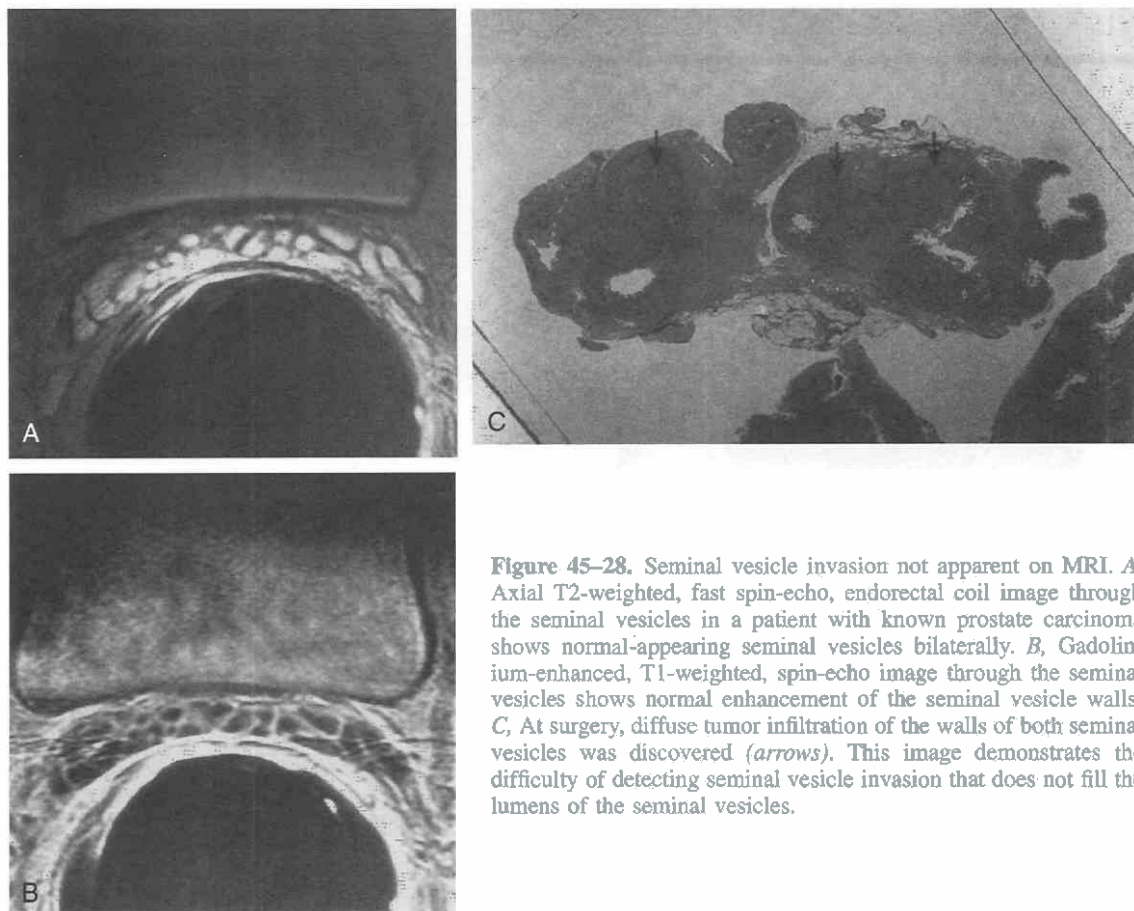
Seminal vesicle invasion not apparent on MRI. *A*, Axial T2-weighted, fast spin-echo, endorectal coil image through the seminal vesicles in a patient with known prostate carcinoma shows normal-appearing seminal vesicles bilaterally. *B*, Gadolinium-enhanced, T1-weighted, spin-echo image through the seminal vesicles shows normal enhancement of the seminal vesicle walls. *C*, At surgery, diffuse tumor infiltration of the walls of both seminal vesicles was discovered (arrows). This image demonstrates the difficulty of detecting seminal vesicle invasion that does not fill the lumens of the seminal vesicles.
